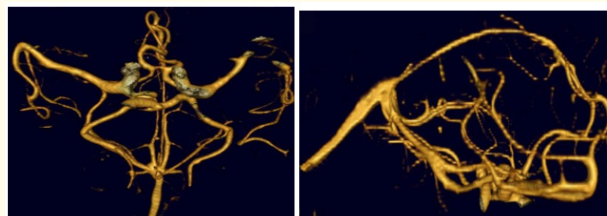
a. C,T Brain Angio; b. CT Brain Angio - Lateral View.
